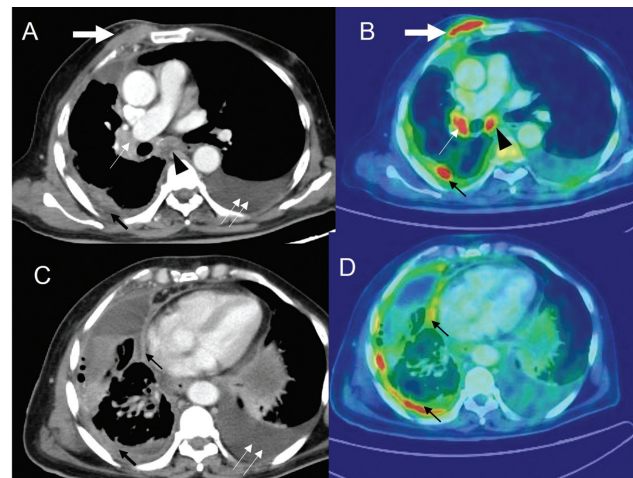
Patient with adenocarcinoma of the lung with positron emission tomography-computed tomography (PET-CT) imaging. CT thorax (A and C) and corresponding fluorine-18 fluorodeoxyglucose positron emission tomography (^{18}F -FDG PET) images (B and D) demonstrate chest wall extension (thick white arrow), having standardized uptake value (SUV) of 9.4, enlarged right hilar (thin white arrow) and 7.6, respectively. Pleural effusion with nodular pleural thickening (thin black arrow) with SUV of 6.6. Moderate amount of pleural effusion (double thin white arrows) on the left side.
